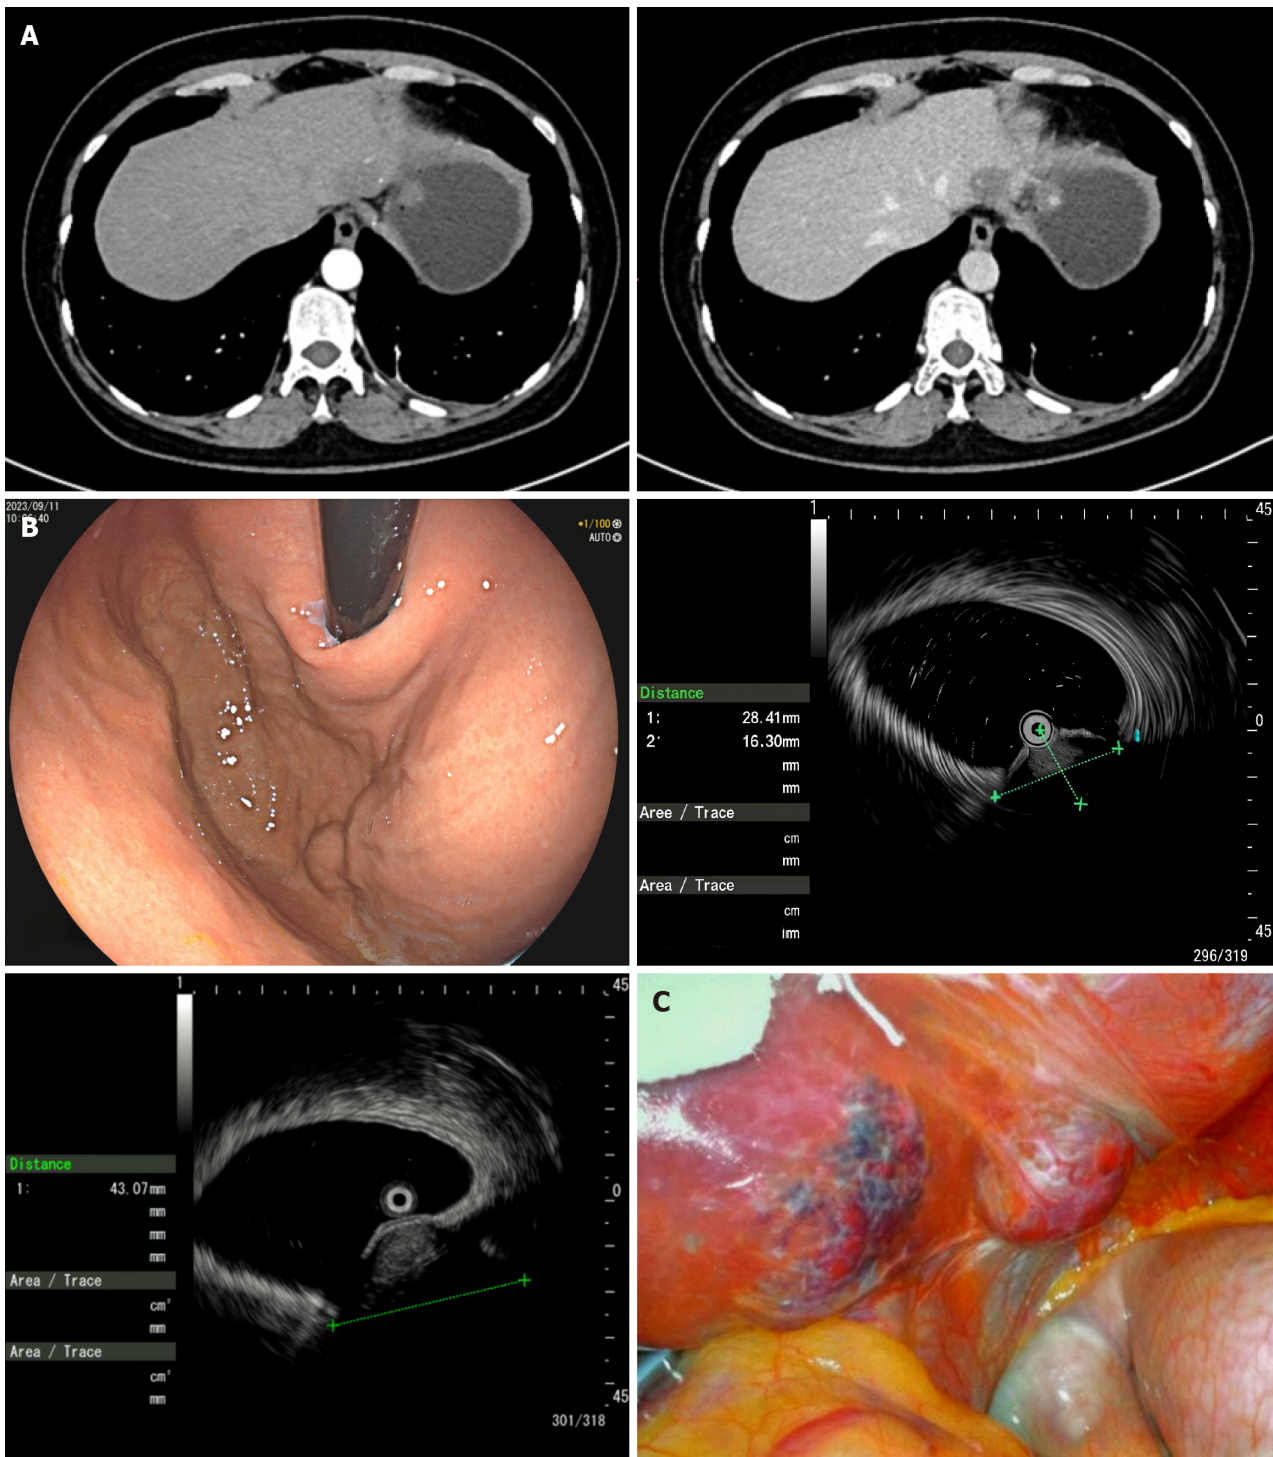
The patient's imaging examination and laparoscopy. A: Enhanced computed tomography image of two circular nodules in the fundus of the stomach; B: Endoscopic ultrasound image of two connected spherical bulges in the anterior wall of the fundus of the stomach; C: Laparoscopic visualization of two unexpected lesions in the left lobe of the liver.
